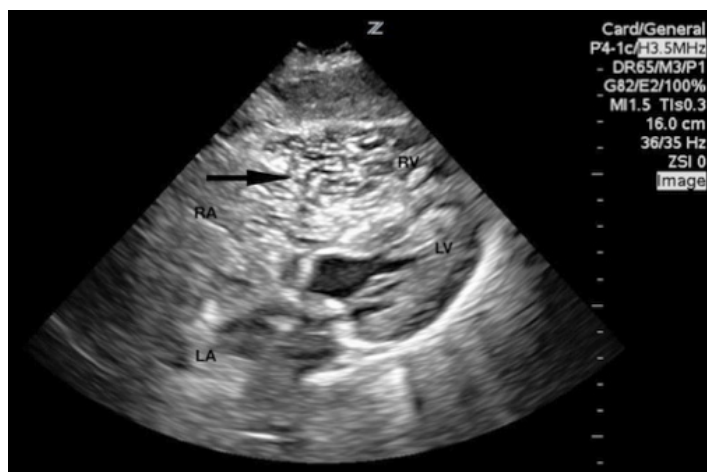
A subcostal cardiac view demonstrated normal left ventricle (LV) contractility, decreased right ventricular (RV) contractility, and RV dilation greater than 1.5 times the LV diameter. Copious hyperechoic mobile bodies were noted within the right atrium (RA) and RV (black arrow). A parasternal short view, not pictured, revealed LV septal in-bowing during systole and diastole. LA, left atrium.
